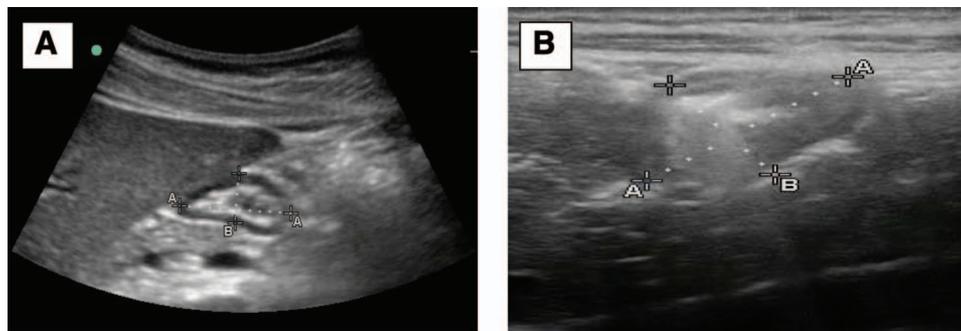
Example of gastric ultrasonographic images. (A) Before facemask ventilation. (B) After gastric insufflation with typical aspect of comets tail artifact.
